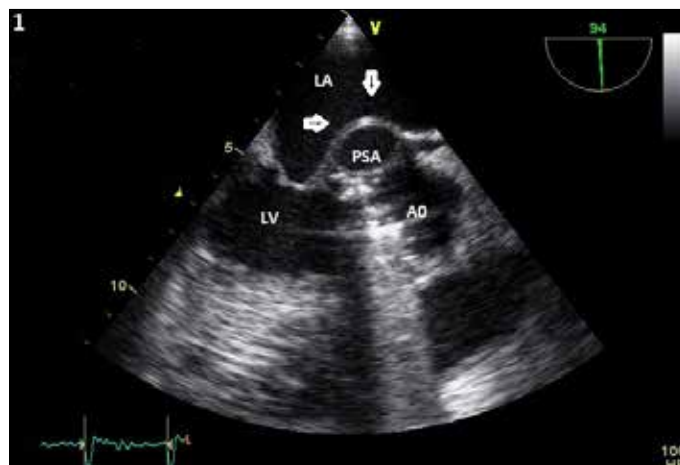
The transesophageal echocardiography image shows a pseudo-aneurysm, bulging from aorta to left atrium (arrows)
